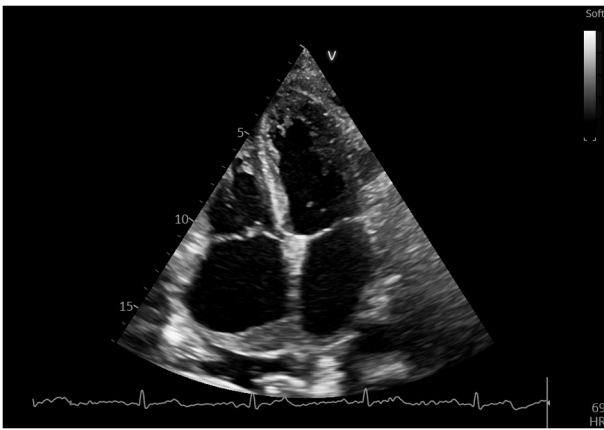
Echocardiographic slightly modified apical four chamber view made 5 days after chemotherapy initiation showing a remnant of the tumoral mass, observed at the base of the interatrial septum; however, it was much smaller in comparison with the evaluation before chemotherapy initiation. HR, heart rate.
